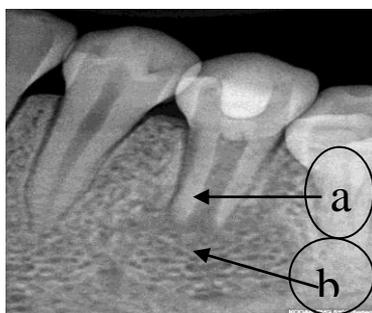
2 years post operative view of 45 indicating thickening of the lateral dentinal wall (a) and almost complete resolution of the periapical lesion in relation to the tooth (b).
